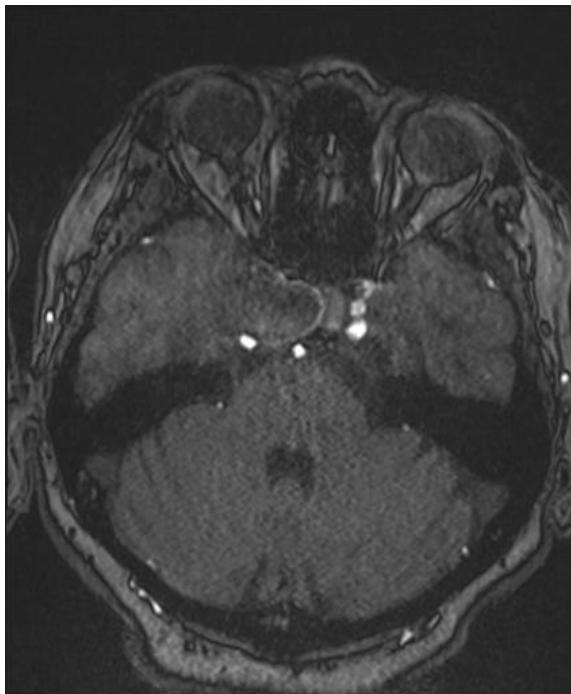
An MRI image of a right partially thrombosed cavernous carotid aneurysm with compression of cranial nerves.
